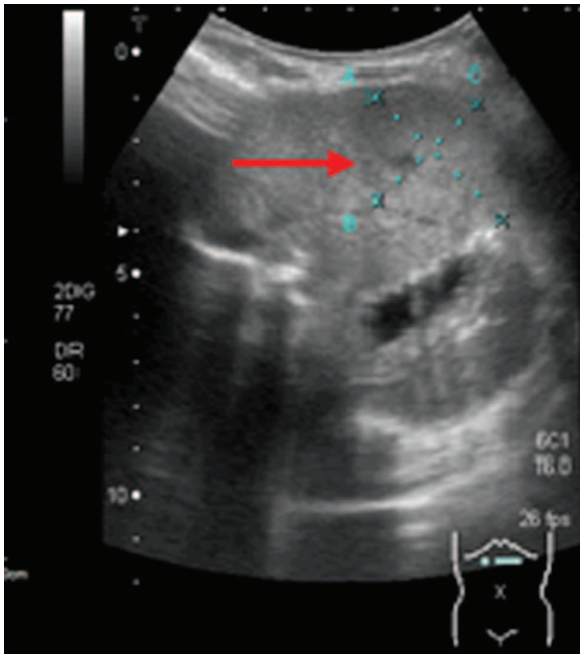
An abdominal ultrasound examination showed multiple hepatic heterogeneous mass lesions, with the largest one in size of 40.6*32.1 mm (arrow).
